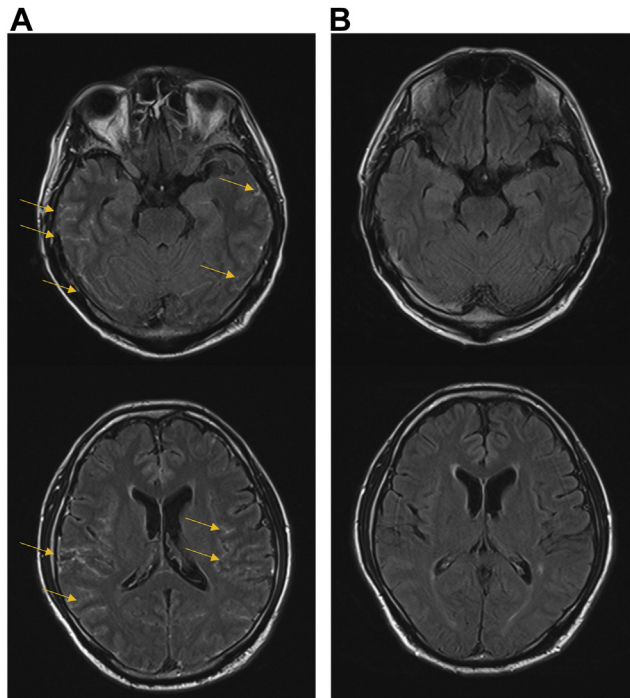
Findings of fluid-attenuated inversion recovery magnetic resonance imaging after angiography in case 3 immediately after onset of depressed consciousness (A) and 4 days after the administration of methylprednisolone (B). Abnormal enhancements were found along the lines of the corpus callosum in Figure 1A (yellow arrows), which disappeared in Figure 1B.
